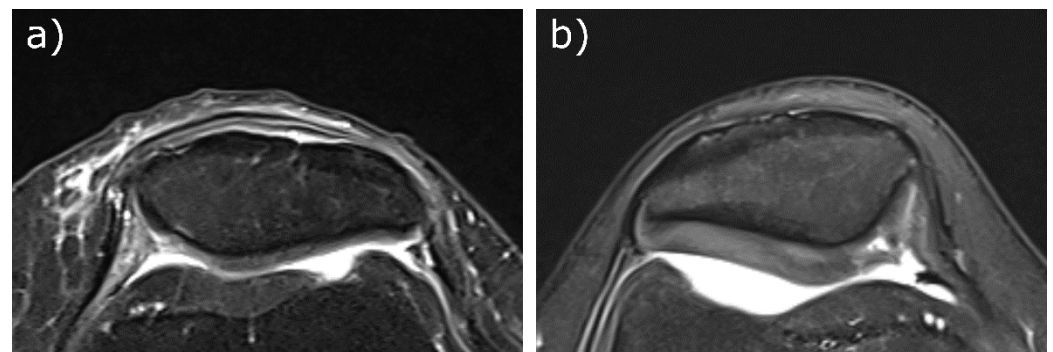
Transversal Proton Density-weighted fat-saturated images of the two patients. (a) Patient (female, 66 years, left knee, protocol 1) with moderate long-distance cartilage loss medial and lateral (10–75% of the subregion) and medial short-distance (<10% of the subregion) full-thickness defect (MRI Osteoarthritis Knee Score (MOAKS): (2/1) medial, (2/0) lateral). (b) Patient (female, 30 years, right knee, protocol 2) with very long-distance cartilage loss medial (>75% of the subregion) with short-stretch full-thickness defect (<10% of the subregion) and short-stretch, full-thickness lateral defect (<10% of the subregion), the latter is not visible in the depicted slice (MOAKS: (3/1) medial, (1/1) lateral).
